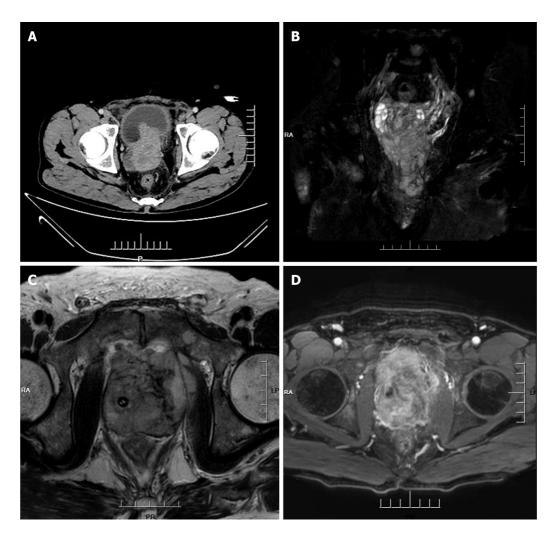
Computed tomography imaging and magnetic resonance imagining. A: Computed tomography imaging of the abdomen: Heterogeneous density within the prostate and heterogeneous enhancement after enhancement, suggesting possible prostate cancer, possible pelvic lymph node metastasis, pelvic floor fascia, and rectal wall and seminal vesicle invasion; B-D: Prostate magnetic resonance imagining: Mixed signals in the prostate, with possible prostate tumor invasion of the lower posterior bladder wall, rectal mesentery, and bilateral seminal vesicles, with multiple lymph node metastases in the pelvis.
